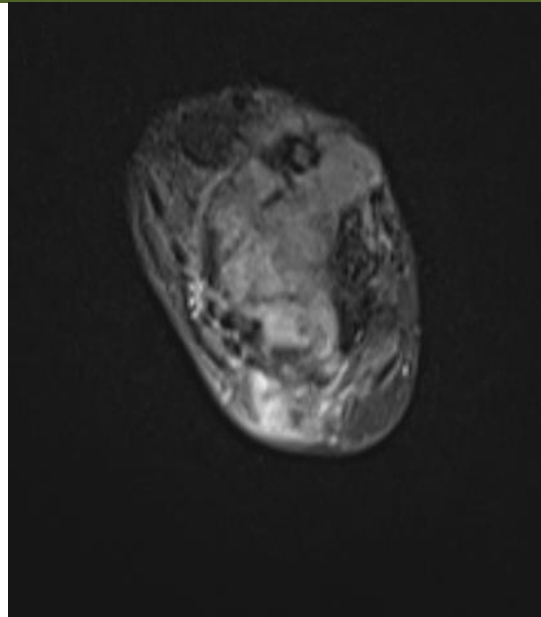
AXIAL STIR MRI sequence demonstrating marked hyperintensity of the lesion, reflecting high free water content associated with edema and myxoid stroma. The lesion measures approximately 85 mm in greatest dimension
